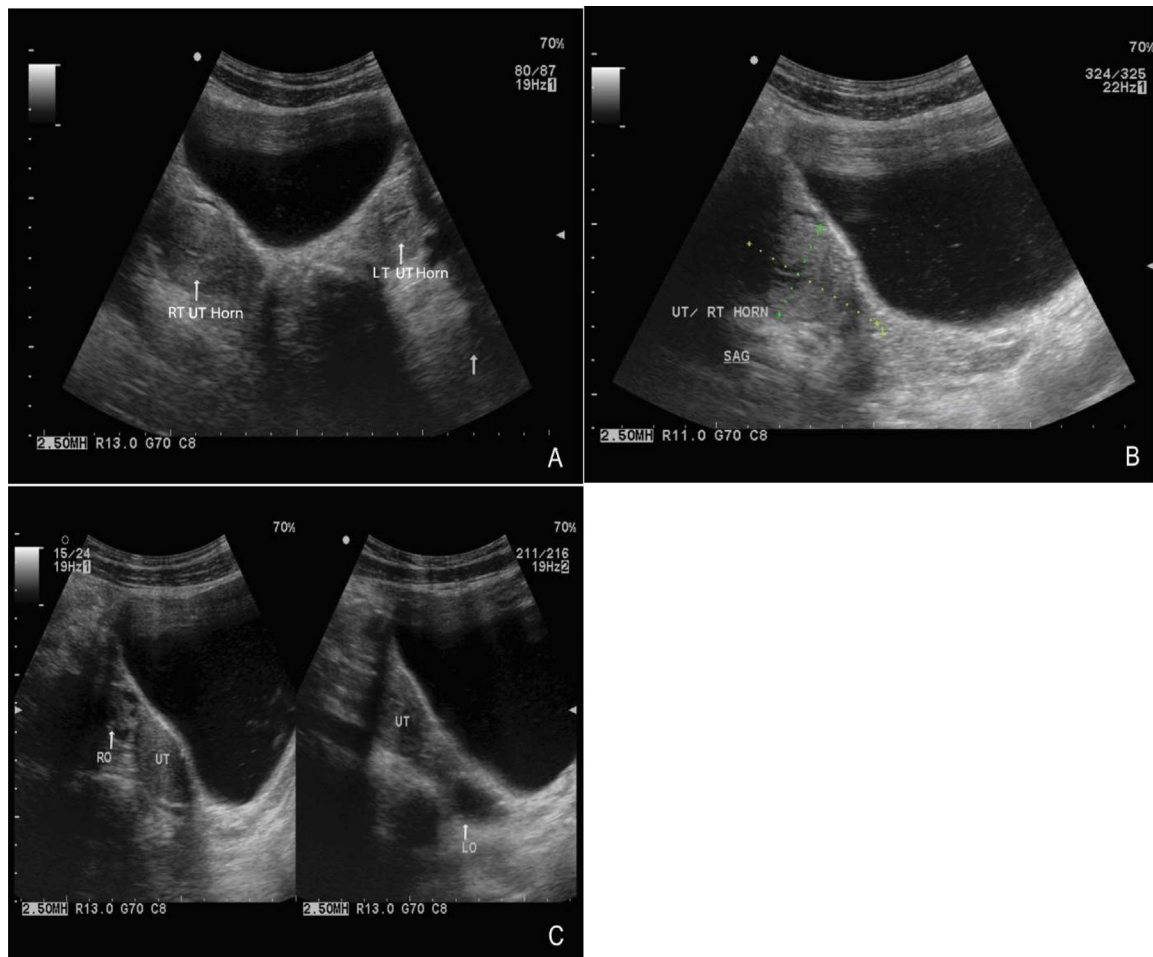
Transabdominal ultrasound in 2017 and 2023 done for the patient demonstrating similar findings. (A) show widely separated 2 uterine horns with normal myometrial echogenicity and central thin echogenic endometrial stripe on either side (White arrows). (B) On the longitudinal view, no cervix or upper vagina could be seen. (C) show bilateral normal appearing ovaries containing physiological follicles (White arrows). No abnormal pelvic masses.
